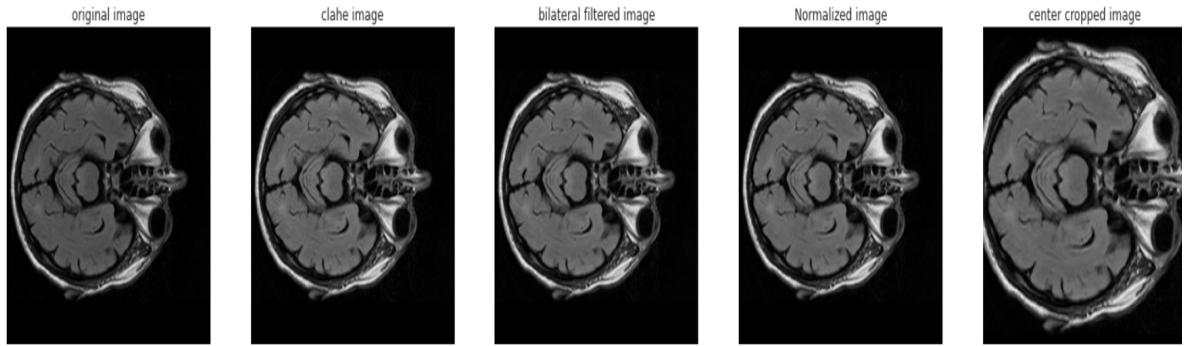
Types of brain MRI-scanned images*
